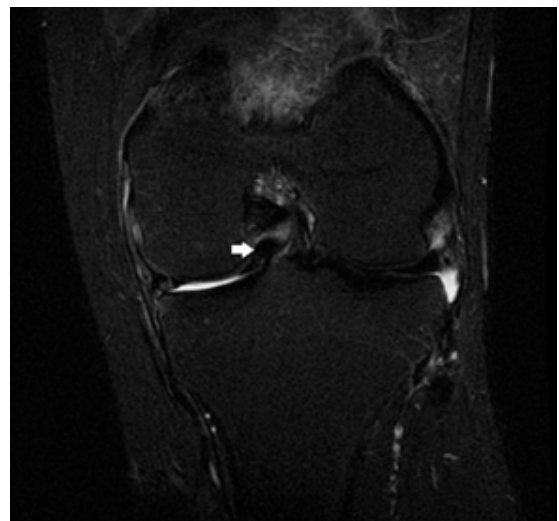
Coronal magnetic resonance imaging demonstrating a displaced medial meniscal fragment within the intercondylar notch.
